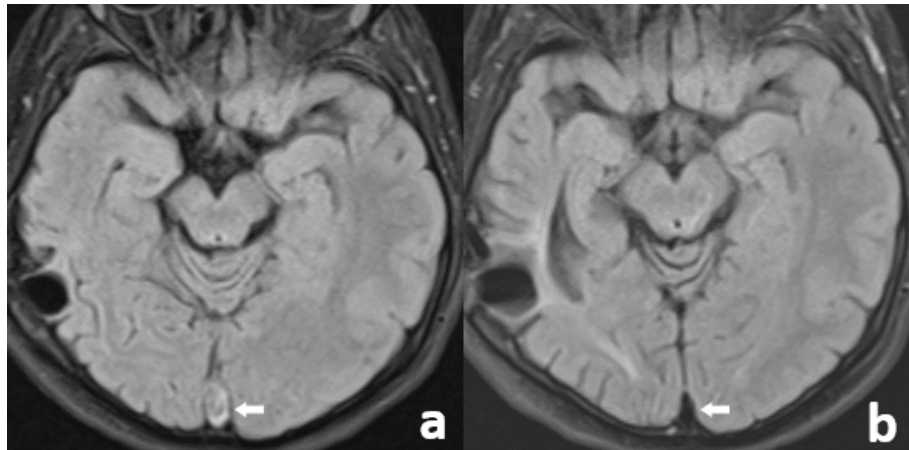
a. Absence of normal flow void in the superior sagittal sinus on FLAIR image. Note the expanded sinus. b. Normal flow void in the same localisation on the third week of medical treatment.
